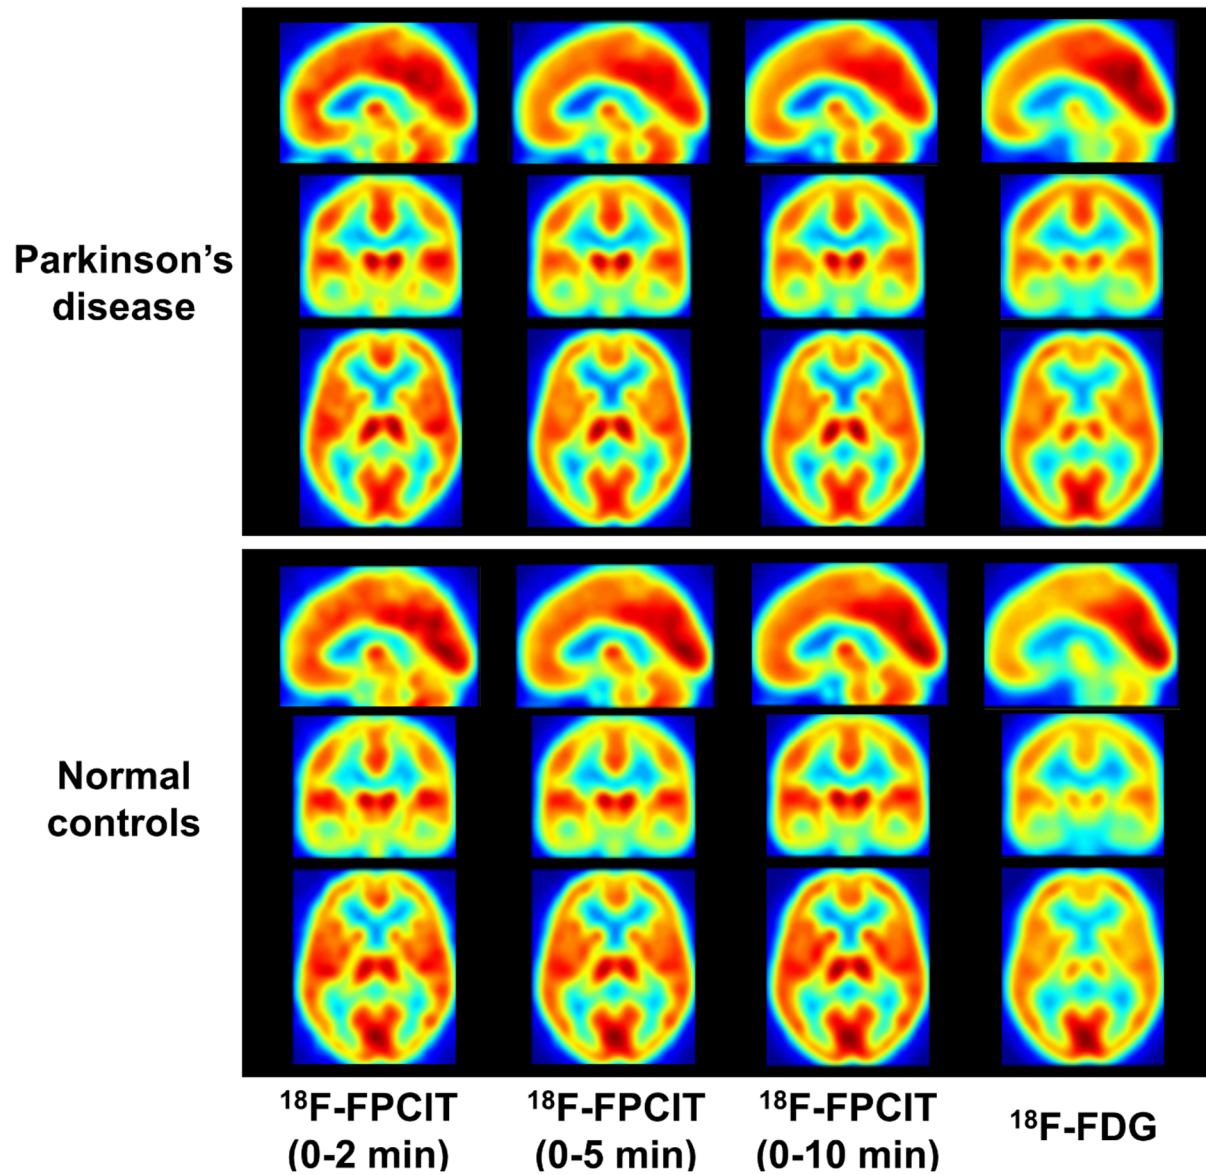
Mean images in PD patients and normal controls from early-phase ^{18}F -FPCIT and ^{18}F -FDG PET. There was high similarity between the mean images of ^{18}F -FPCIT over the first 2, 5 and 10 min post-injection and the corresponding ^{18}F -FDG images.
